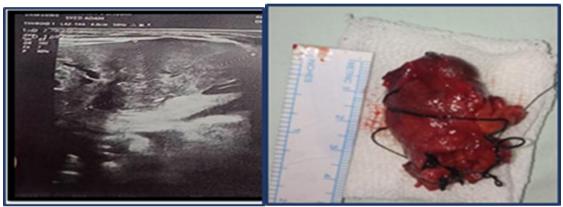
Ultrasonography of lesion
